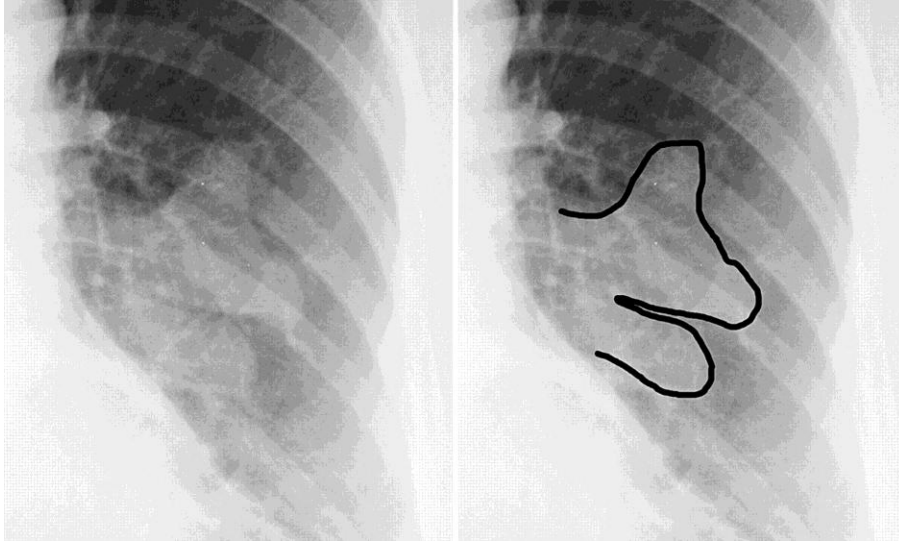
Finger-in-glove sign in a case of allergic bronchopulmonary aspergillosis. Posterioranterior radiograph (left) depicts a homogeneous branching opacity that radiates from the left hilum, a feature perhaps more easily discerned with the aid of a superimposed contour line (right) [2].
